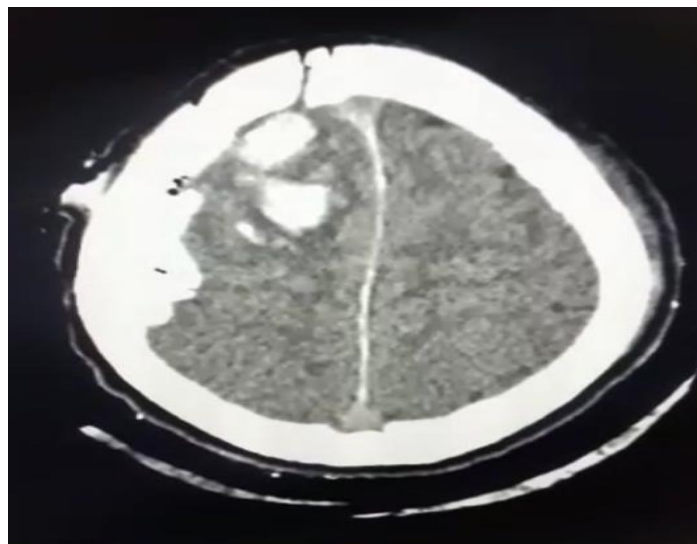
First brain CT scan showing initial injury
